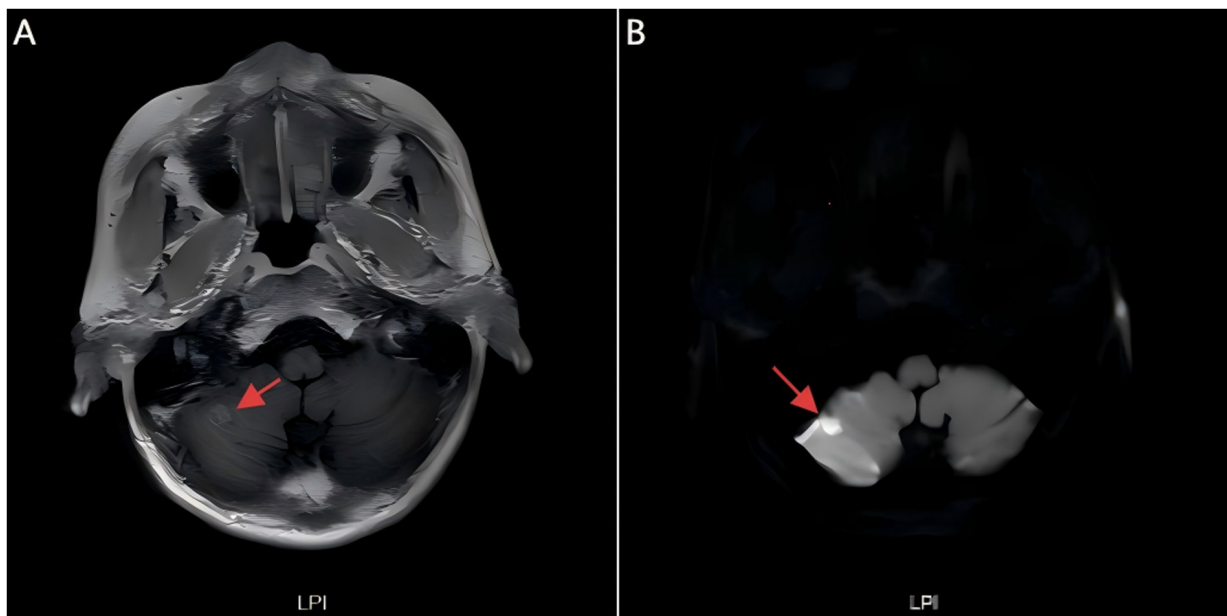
Brain MRI showing abnormal signal in the right cerebellar hemisphere. (A) Axial T1-weighted image (red arrow). (B) Diffusion-weighted imaging reveals a hyperintense lesion (red arrow).
